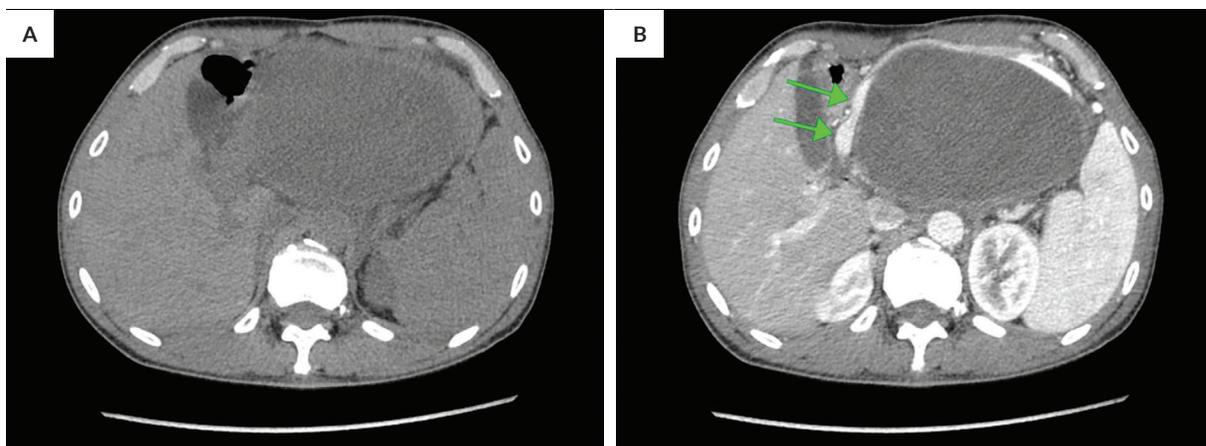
Plain (A) and contrast-enhanced (B) abdominal CT images showing a large cystic pancreatic mass showing compression of the portal vein (green arrows) with a poor plane of differentiation from the pancreatic mass.
